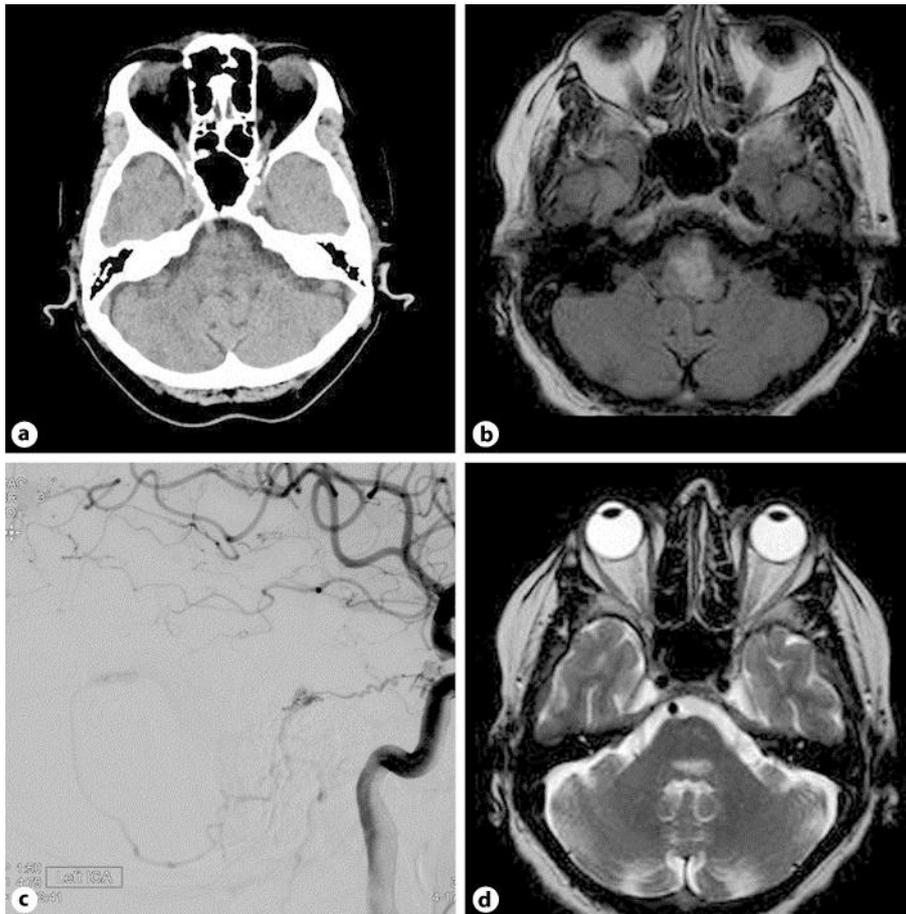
Pre-embolization imaging. a Non-contrast head CT showing subtle medullary edema, evident following review of MRI examination. b Flair sequence with hyperintensity showing medullary edema. c Conventional digital subtraction angiogram demonstrating left ICA injection demonstrating a left tentorial apex dAVF. The fistula was noted to have multiple feeder vessels including the left meningohypophyseal trunk and the petrous branch and posterior division of the left middle meningeal artery. The venous drainage ran inferior along the ventral margin of the cervicomedullary junction. d Axial T2 MRI with hyperintensity showing pontine edema.
